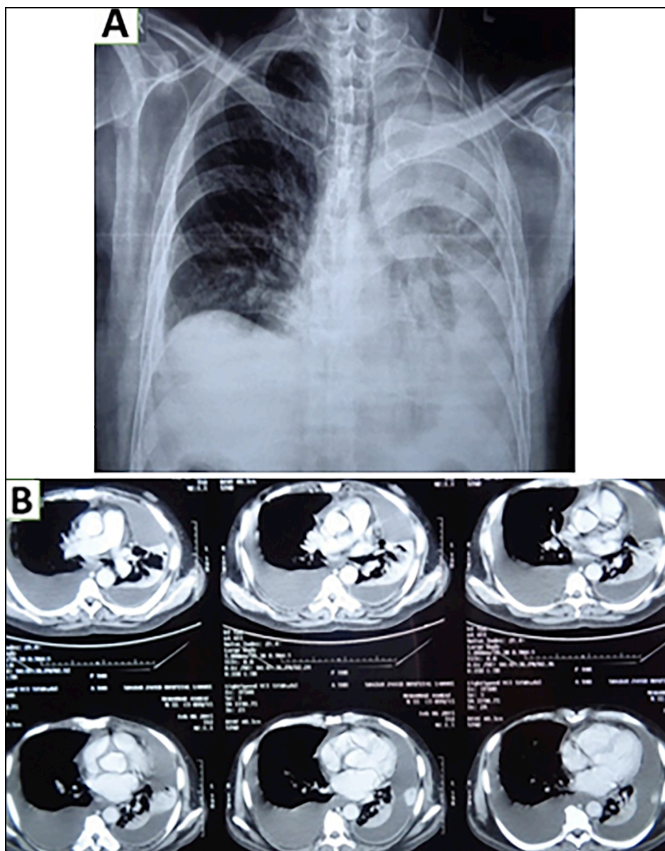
(A) Chest x-ray (PA view) demonstrates a slightly elevated right hemidiaphragm with associated costophrenic angle blunting, indicating a possible pleural effusion. The trachea is deviated to the left, and additionally, there is diffuse opacification in the left upper and lower zones, with intervening lung parenchyma visible. The left hemidiaphragm is obscured, consistent with a large pleural effusion. (B) Contrast-enhanced computed tomography (CECT) scan reveals a small, free-flowing pleural effusion on the right side with a curved upper margin. In contrast, the left side shows a loculated pleural effusion with a collapsed lung in the middle, and an enhanced parietal pleural surface, indicative of inflammation.
